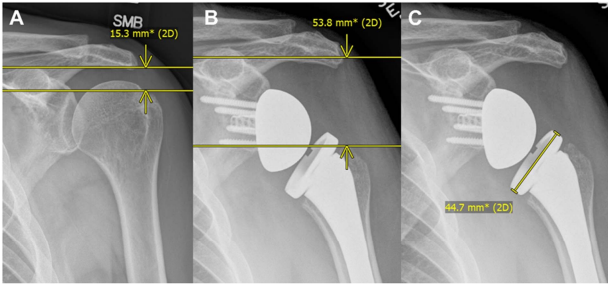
The change in subacromial height was computed as the difference between the preoperative (A) and postoperative (B) subacromial height. Radiographic magnification was corrected for by multiplying radiographic measurements by the ratio of the known to measured adapter diameter (C).
